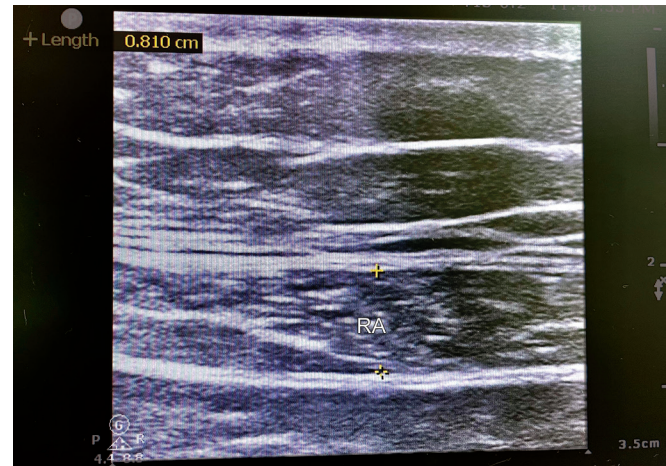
Ultrasound image in a patient showing the thickness of the rectus abdominis (RA) muscle
